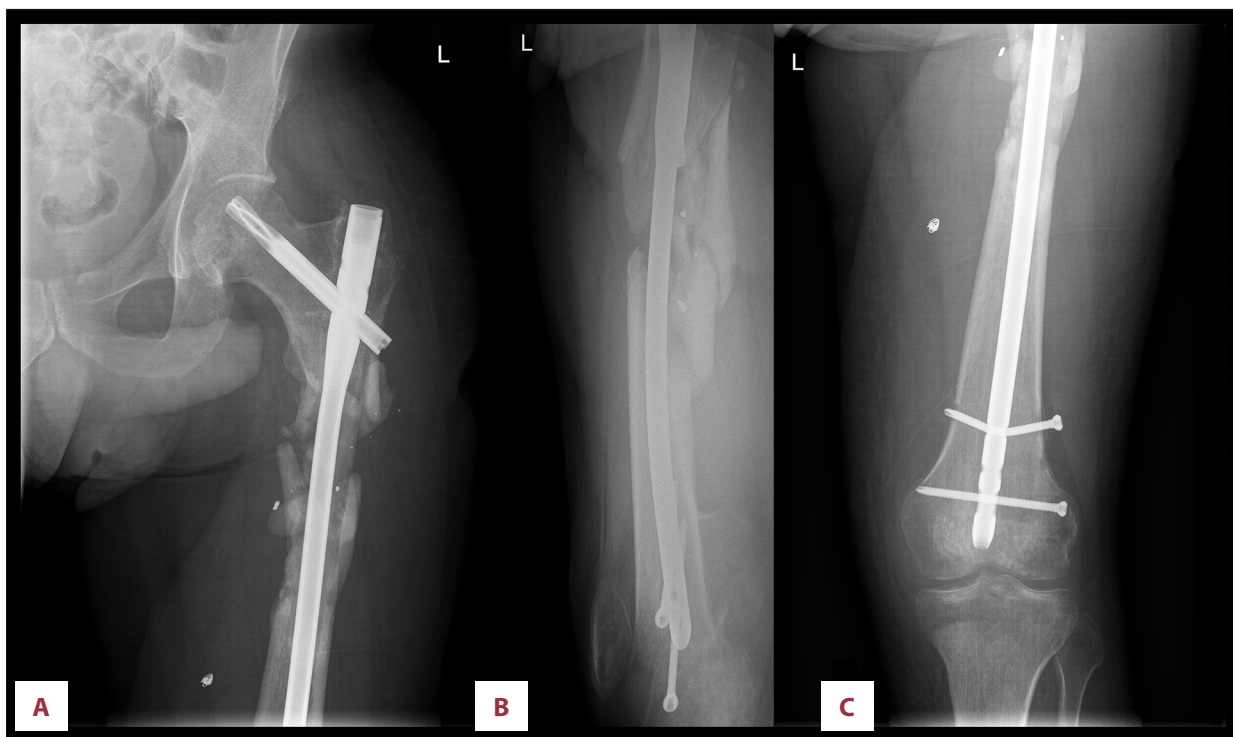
Radiographic findings on admission. X-rays (anteroposterior [A], lateral [B], anteroposterior [C]) showing the damaged limb after osteosynthesis with a long gamma nail and 2 intraosseous screws, fracture of the proximal screw, and minimal callus formation at the fracture site.
